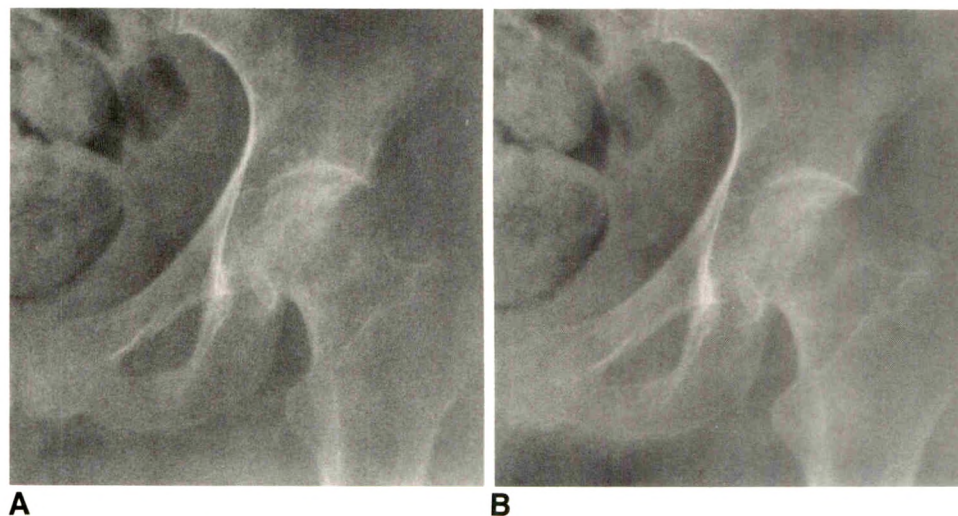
A, Original radiograph of pelvis of 32-year-old man with impacted fracture of neck of left femur.
